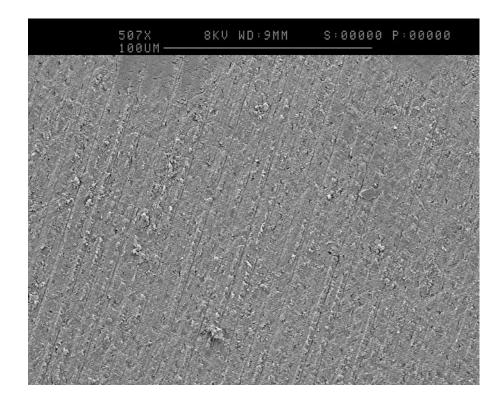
SEM image (500x magnification) to show Hülsmann score 4, in Group 2, treated by ultrasonication in distilled water for 15 minutes.
